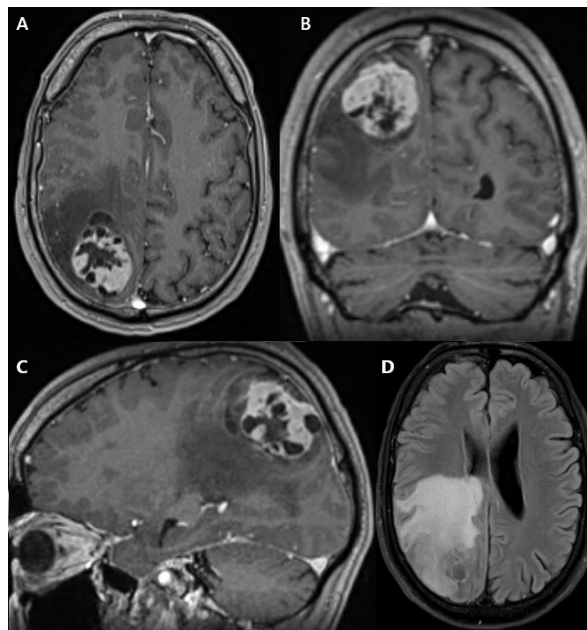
Right parietal tumor with heterogeneous gadolinium enhancement (A)-(C) and perilesional edema visible in FLAIR (D).
